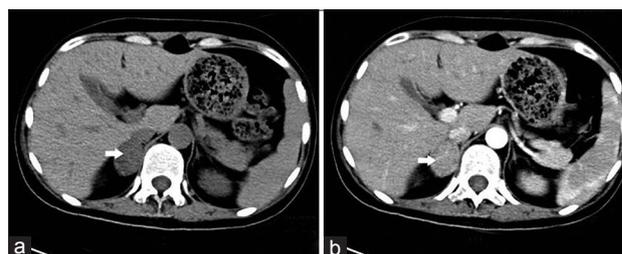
(a) Computed tomography (CT) of the abdomen shows a 2.5 cm \times 3.5 cm sized, well-defined mass in the right adrenal gland; (b) Contrast-enhanced CT of the abdomen shows an enhancing mass.
